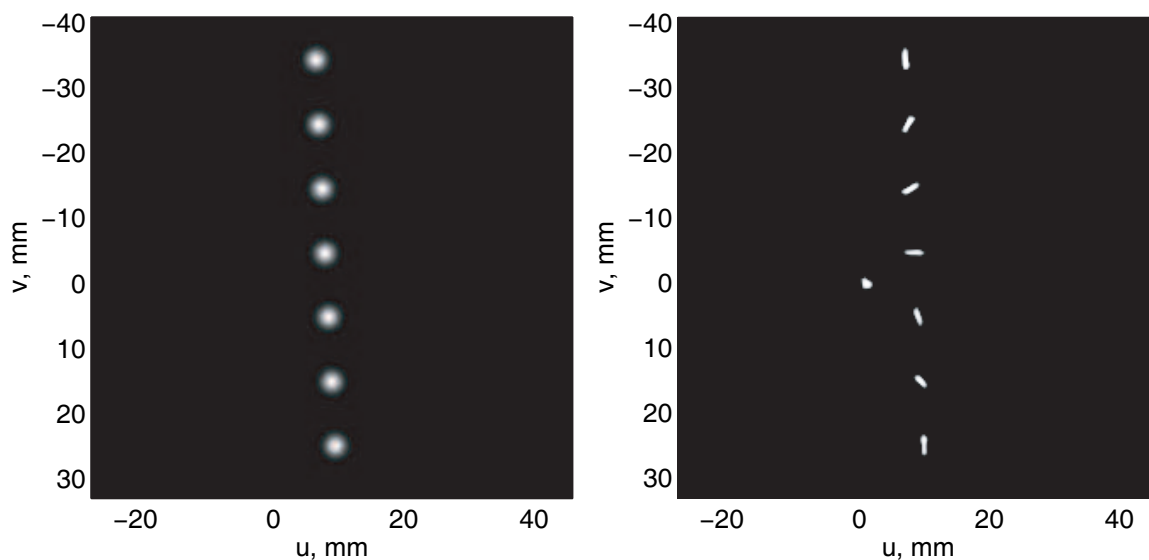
Marker splat DRR generated from a CBCT image of the RSVP (*left*) and a corresponding MEF-image (*right*).
